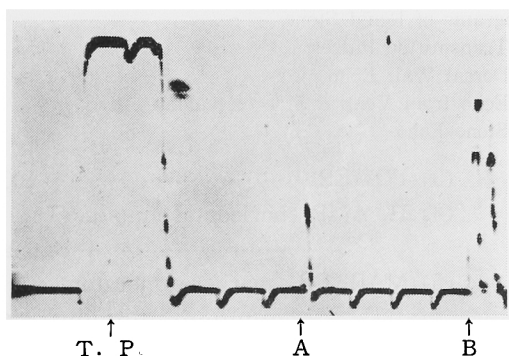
Ultrasono-echogram of Stone (C) Hanging in Water.
